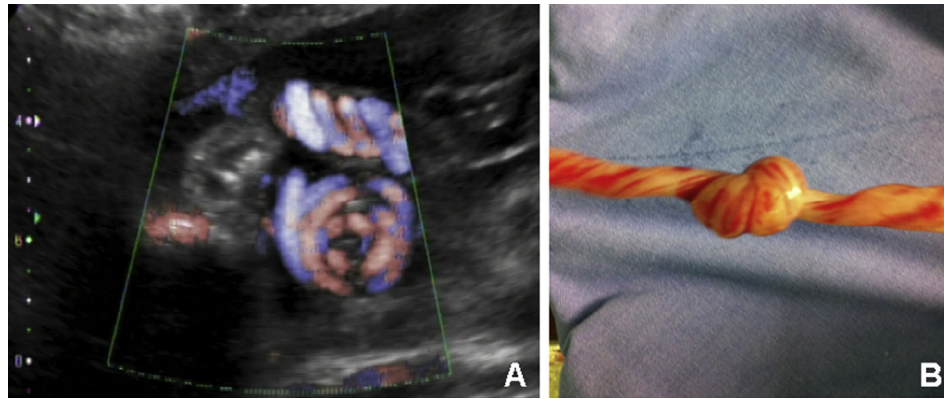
(A) Doppler ultrasound showing the appearance of the true umbilical cord knot, with evidence of the “loop” sign. Interestingly, in the same image, a portion of the normal umbilical cord above the true umbilical cord knot can be observed. (B) Visualization of the postnatal appearance of the umbilical cord, with evidence of the true knot.
